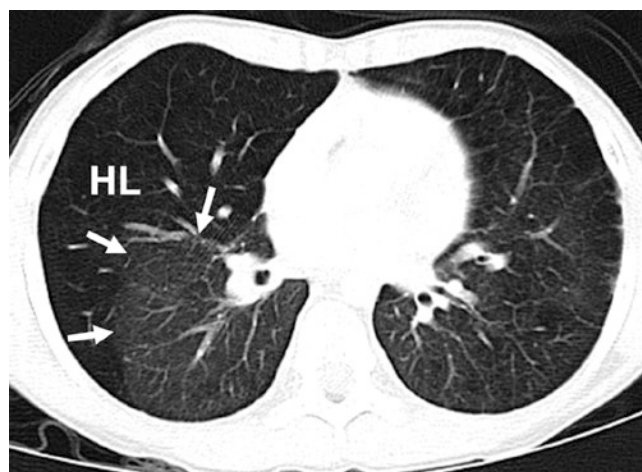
Ten-year-old girl with idiopathic pulmonary hypertension who initially presented with syncope and shortness of breath. Axial lung window CT image demonstrates geographic areas of ground-glass opacification (arrows) and hyperlucency (HL)
